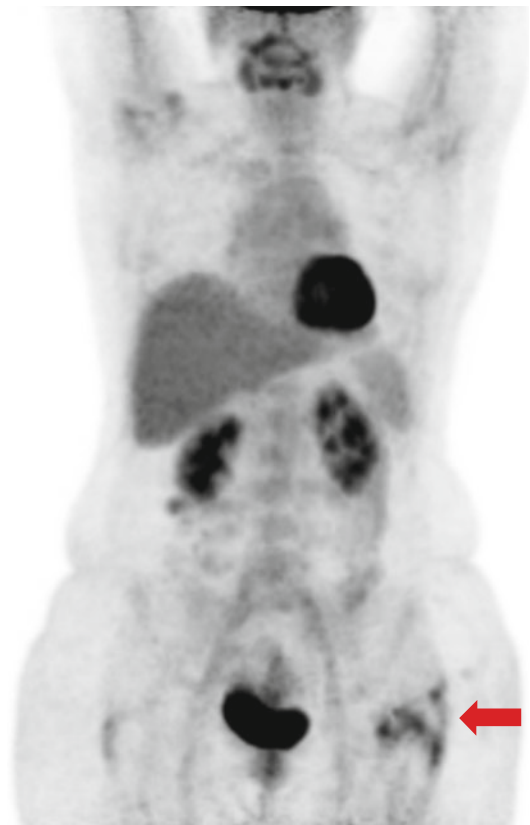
Whole-body PET maximum intensity projection (MIP) image reveals abnormal increased FDG activity in the intertrochanteric region of the left proximal femur (*red arrow*). There is no FDG-avid disease elsewhere
